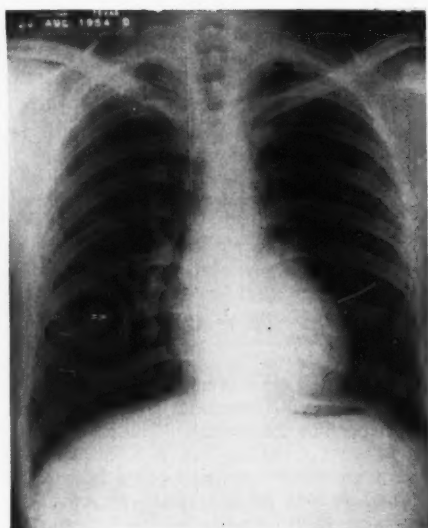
Roentgenogram of the chest nine months after pericardiectomy, showing a normal cardiac silhouette.
